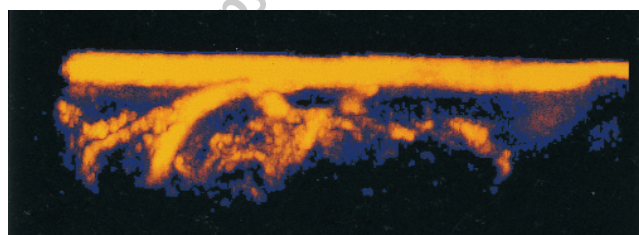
3D power Doppler image.
